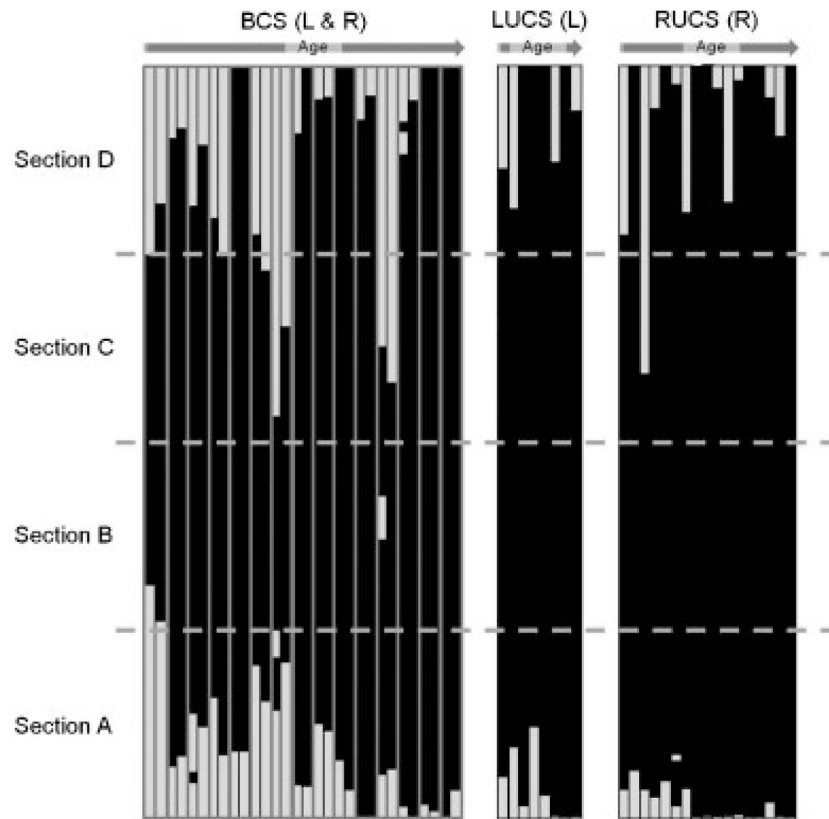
Coronal suture fusion patterns by phenotype and age. Each bar represents one side of the coronal suture. For the BCS cases, each doublet of bars represents the left, then right suture (the two bars corresponding to one individual being framed in grey). Only the affected side is shown for the UCS cases. The white and black sections represent the slices where the coronal suture was patent and fused, respectively. Though coronal suture can be represented by 20 or 100 slices depending on the CT slice thickness, all bars have been resized to a common height.
